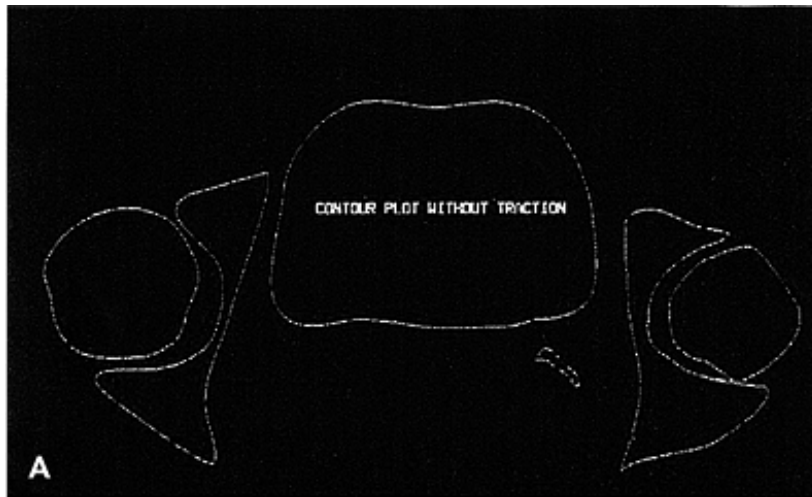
A: Magnetic resonance imaging (MRI) studies of ureteral movement when downward traction is placed on the uterus. Ureter position is seen on the right. B: Overlay of MRI films. Traction on the uterus with a brass tenaculum is applied to the cervix. Note indentation to the bladder from the uterus and lateral and upward displacement of the ureter compared to the position of the ureter position without traction to the uterus.
